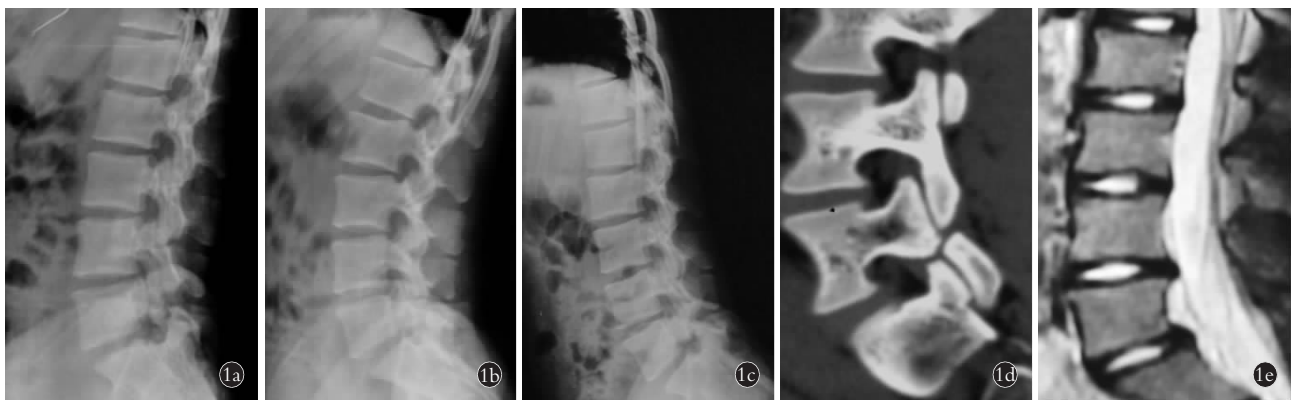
患者,男,18 岁,L₅ 峡部裂,腰椎无滑脱 1a. 术前侧位 X 线片 1b. 术前过伸位 X 线片 1c. 术前过屈位 X 线片 1d. 术前 CT 重建片 1e. 术前 MRI
